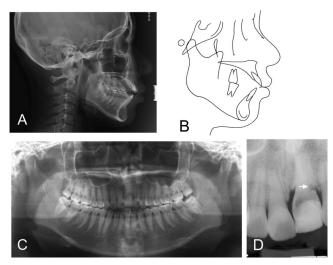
Pretreatment radiographs and tracing. (D) White arrow indicates external root resorption.
